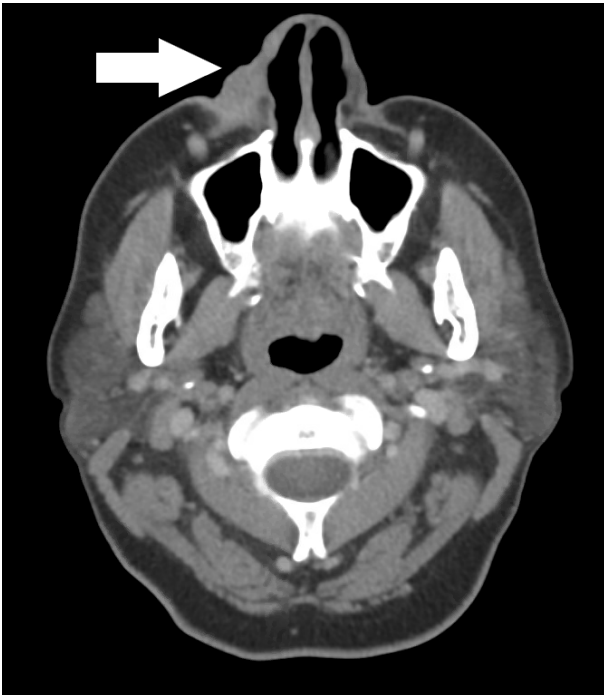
Contrast-enhanced CT of head and neck showing soft-tissue attenuation mass within the right nasolabial fold (white arrow)
